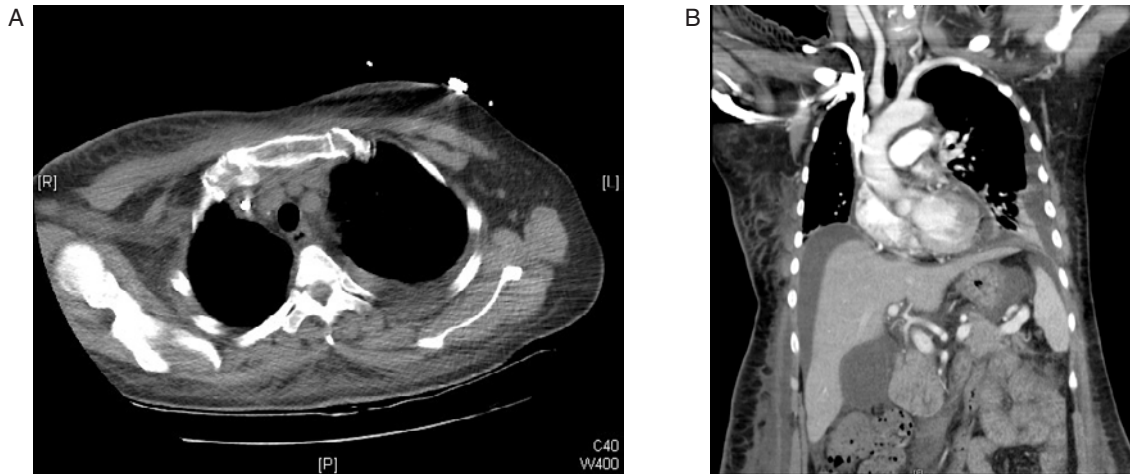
Computed tomography of the chest (A, B), which showed the permanent catheter in the superior vena cava, right pleural effusion.
